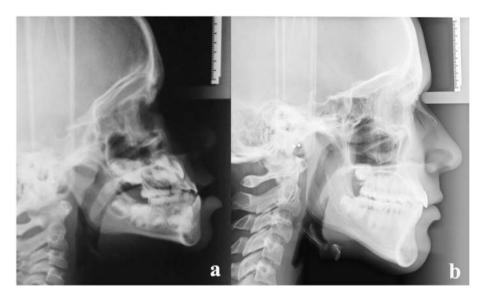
Lateral cephalometric x-rays of patients affected by BWS who did not undergo glossectomy, although it had been offered at the age of 22 months. 4a) Lateral cephalometric x-rays at 5 years. 4b) Lateral cephalometric x-rays at 15 years. Note: This patient was treated with a facial mask for maxillary protraction at age 7 years and subsequently retreated with the Alt-Ramec technique (Meazzini et al., 2019) at age 12.3 y for protraction of the maxilla. The improvement in maxillo–mandibular relation is, therefore, related to maxillary changes and not to mandibular growth. The patient does not need orthognathic surgery.
